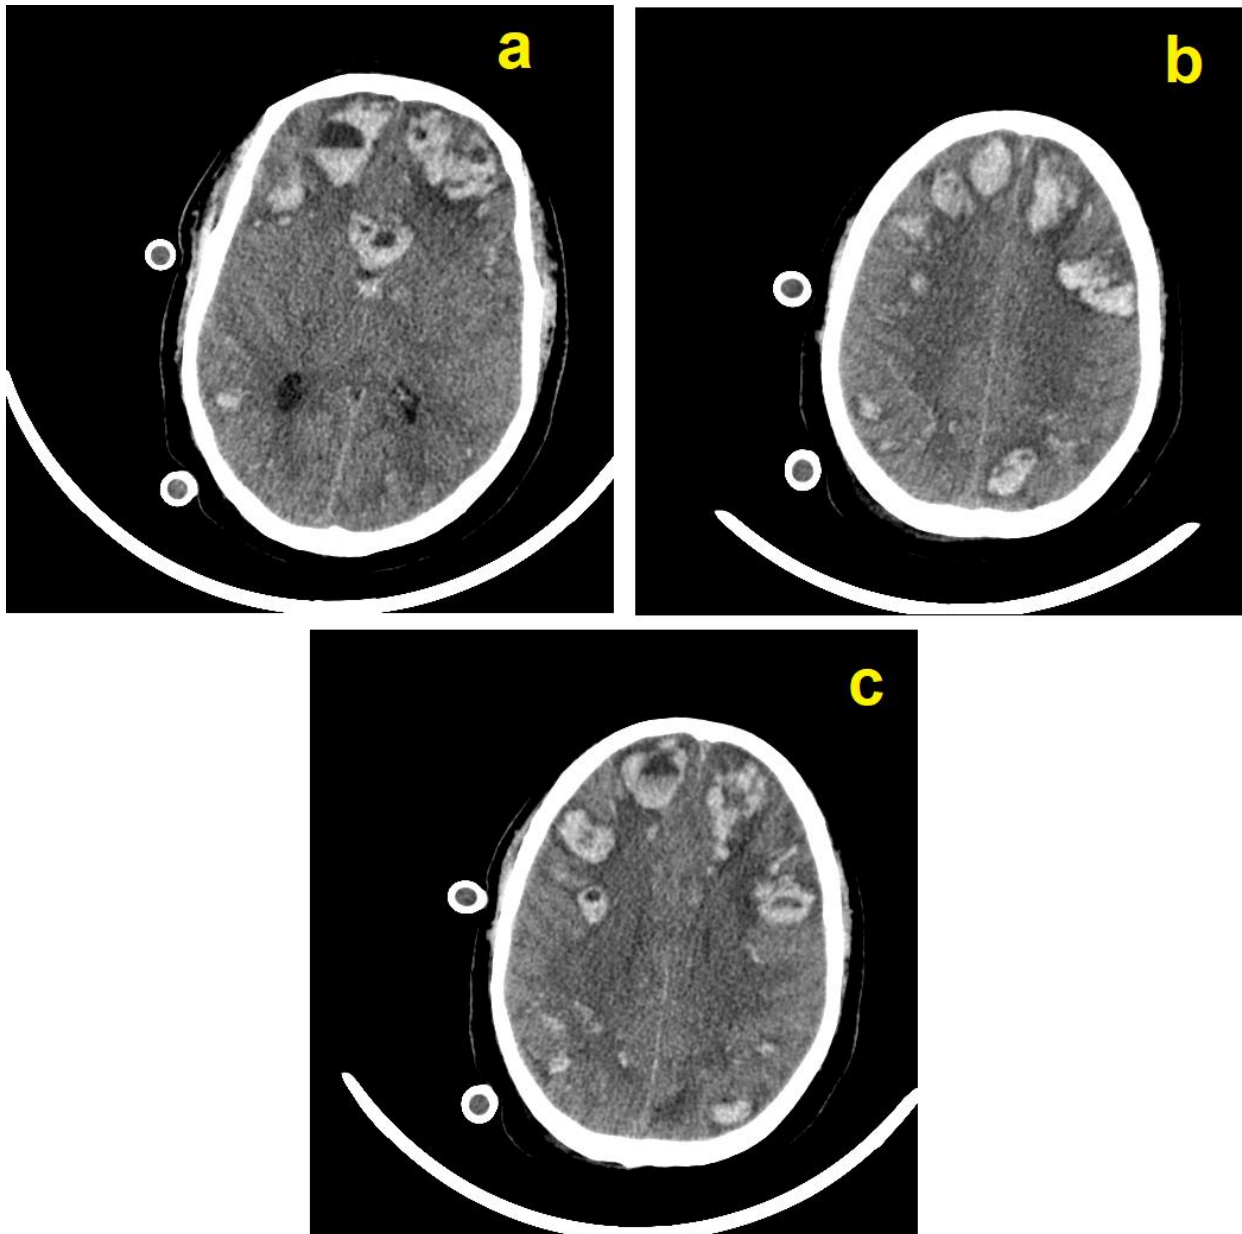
(a, b and c): CT-brain plain
